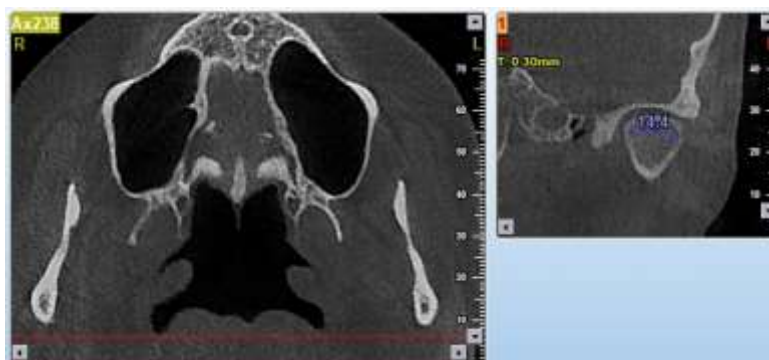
Measurement of condylar width in left side of 22 years old female on CBCT in coronal section.
